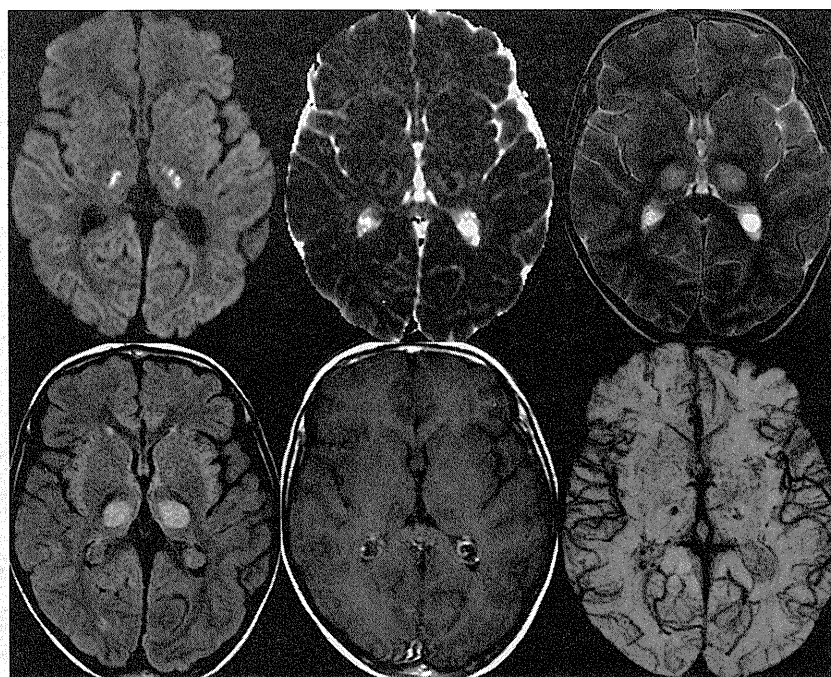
MRI at 26 months. (A) Axial diffusion-weighted image; (B) Axial ADC map; (C) axial T2-weighted image; (D) Axial FLAIR image; (E) Contrast-enhanced axial T1-weighted image; (F) Axial susceptibility-weighted image. MRI shows relapse of the disease, with findings analogous to those at presentation (compare with Fig. 1), albeit less severe.
